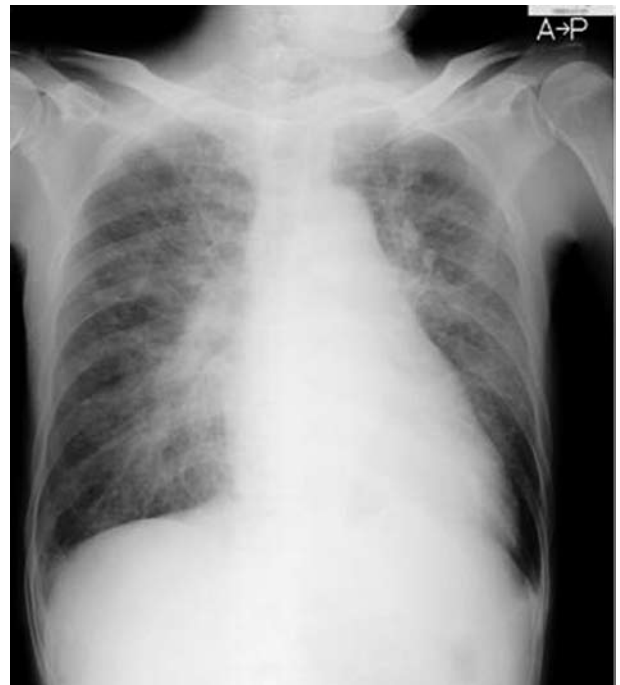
Chest X-ray photograph.
